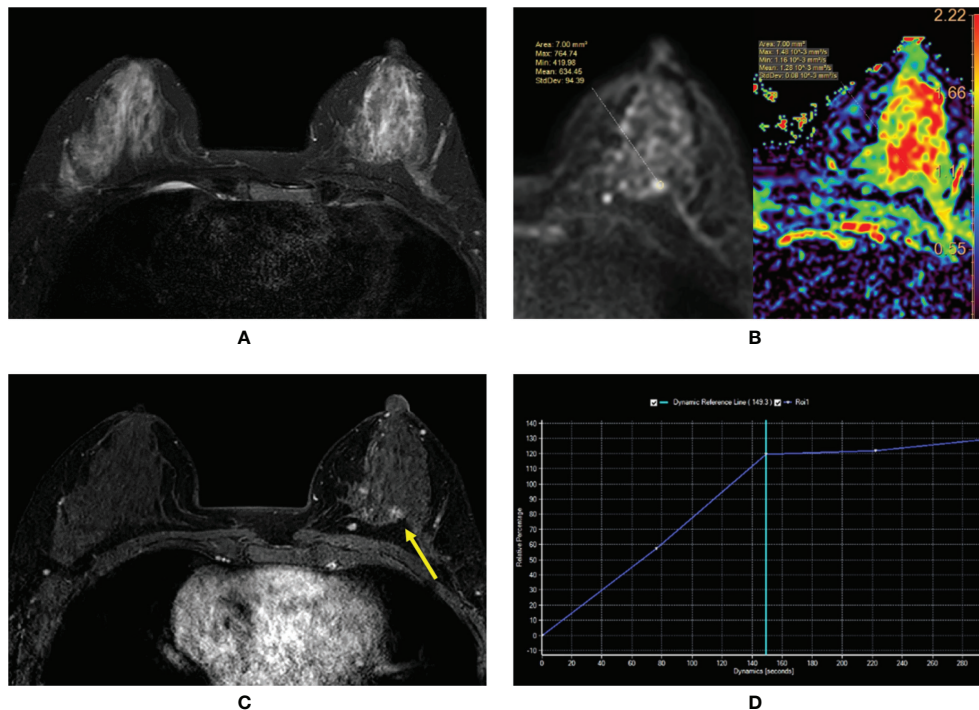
(A–D) Intraductal papilloma with atypical ductal hyperplasia in a 43-year-old woman. (A) T2-weighted image showing an isointensity signal and unclear lesion in the left breast. (B) Diffusion-weighted imaging showing a hyperintensity signal and apparent diffusion coefficient (ADC) map showing mean $ADC = 1.28 \times 10^{-3} \text{ mm}^2/\text{s}$. (C) Enhanced T1-weighted image showing the nonhomogeneous enhancement of an irregular-shaped lesion with ill-defined margins (yellow arrow). (D) Time-signal intensity curve manifests as a rapid increase (initial phases) and a plateau type (delayed phases).
